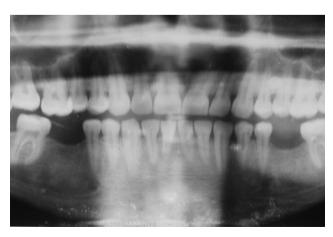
Preoperative OPG radiograph.
